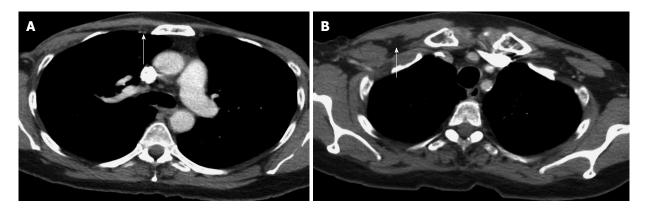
Computed tomography scan of the chest 4 mo after initiation of Adalimumab. A: Resolved internal mammary lymph node (arrow); B: Resolved retropectoral lymph node (arrow).
